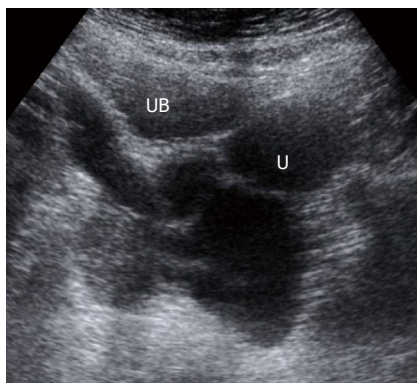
Ultrasound of the pelvis shows a multilocular cystic lesion posterior to the bladder to the left. U: Uterus; UB: Urinary bladder.
